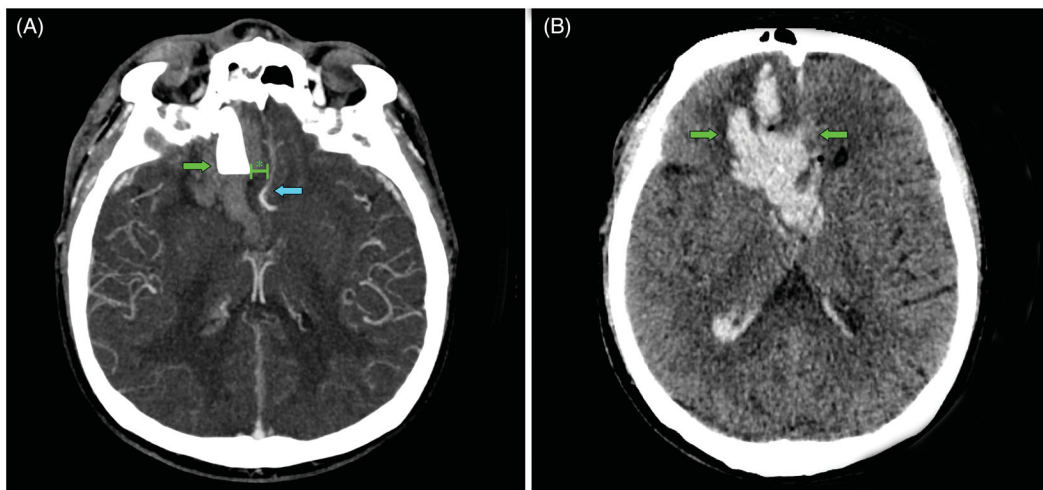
(A) Angio CT scan showing the 9.0 mm distance (*) between the foreign body (green arrow) and the A2 segment of the anterior cerebral artery (blue arrow). (B) Preoperative CT scan showing the frontal intracerebral haematoma (green arrows).
